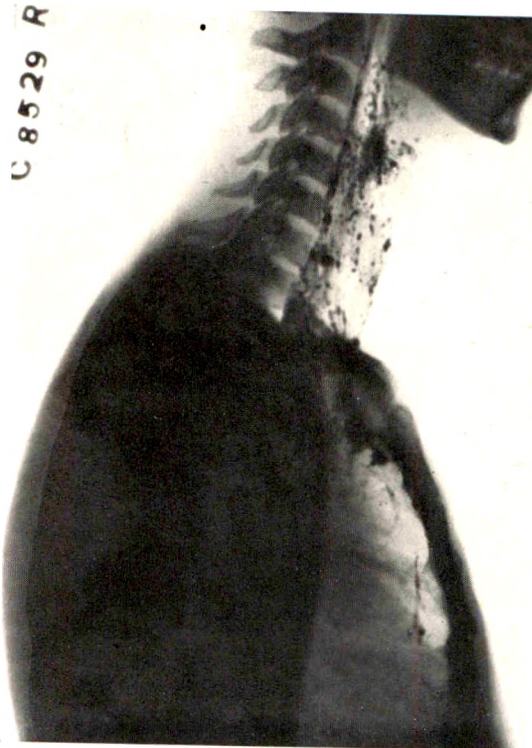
Case S.L. Lipiodol injected by cricothyroid membrane route three years previously. Evidently most of this escaped into the tissues of the neck. Roentgenogram shows lipiodol deposits in the tissues of the neck and also extending low into the mediastinum.
